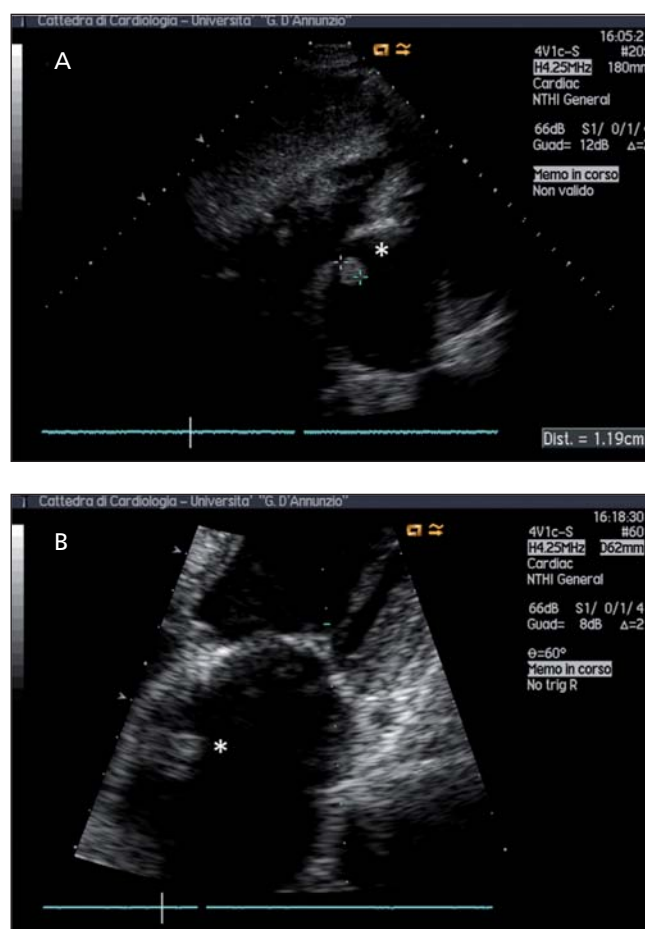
Transthoracic echocardiographic examination performed after the episode of heart failure at admission. An echogenic pedunculated, movable mass, with sharp margins, can be seen in the left atrium, adherent to the interatrial septum (*). A) subcostal 4-chamber view; B) apical 4-chamber view.
